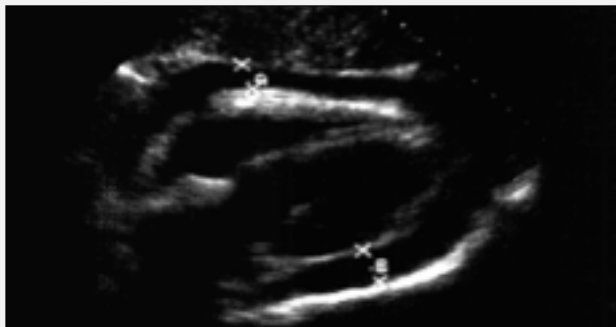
A large pericardial effusion visualized with echocardiography.
